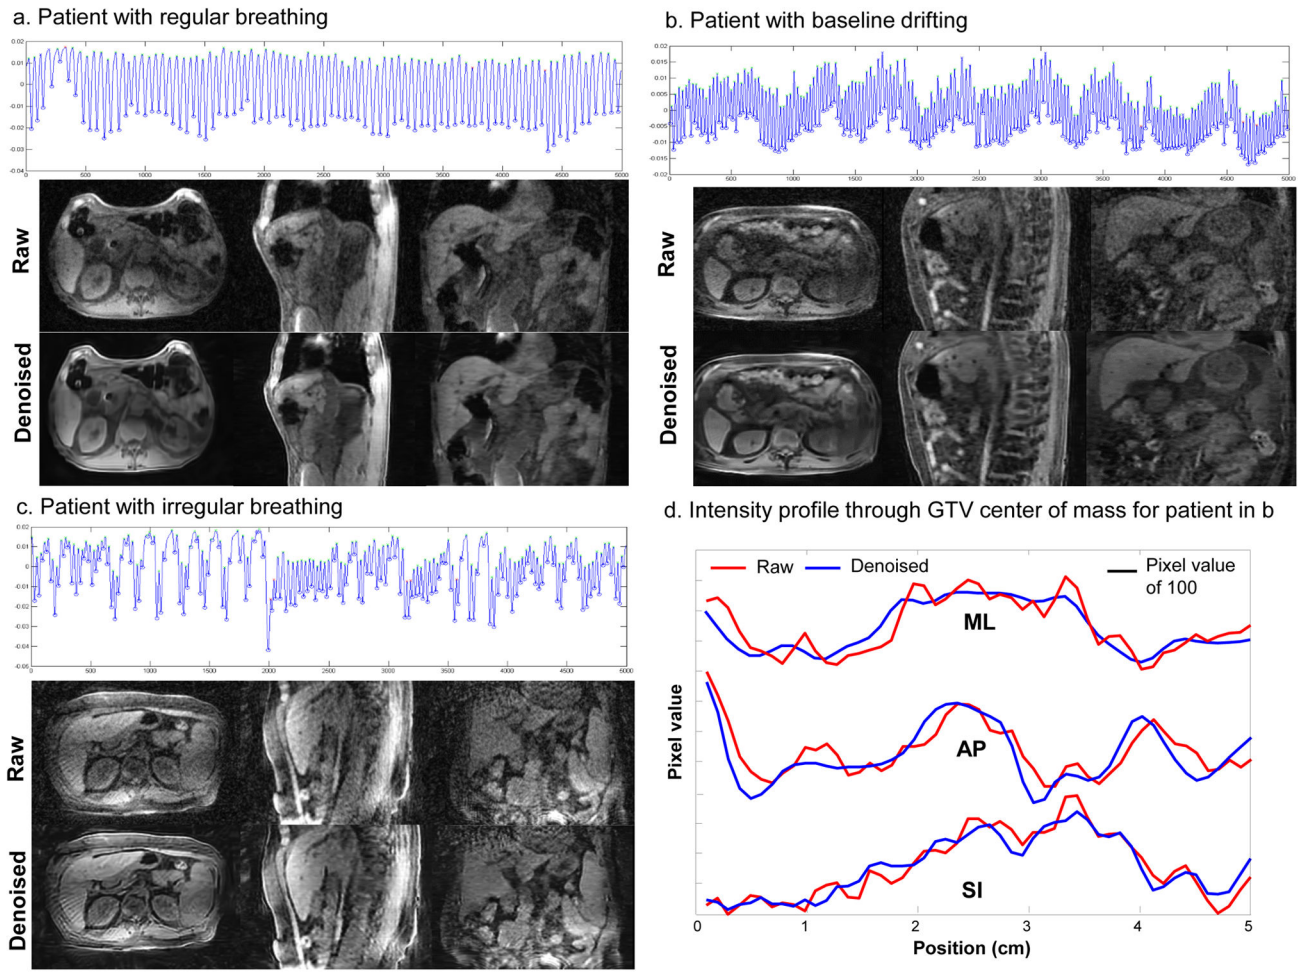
Raw and denoised 4D-MRI for patients with regular breathing (a), baseline drifting (b), or irregular breathing(c) patterns. Intensity profiles (d) across the center of the GTV for the patient in 3b.
